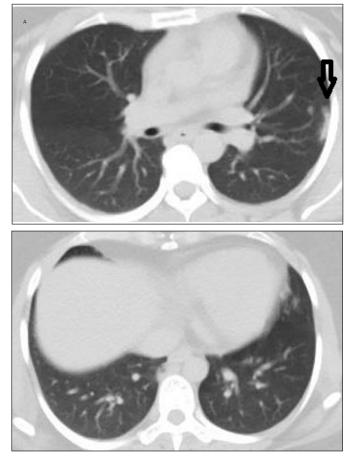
Isolated upper lobe involvement. a. Unenhanced chest CT shows ground glass opacities in the left upper lobe. b. Bilateral lower lobes appear protected
